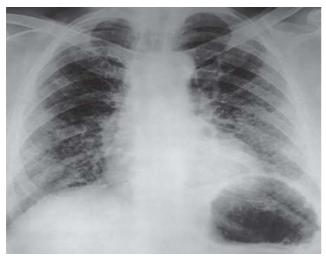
Chest radiograph (postero-anterior view) at the onset of symptoms showing bilateral lower zone mottled appearance.
